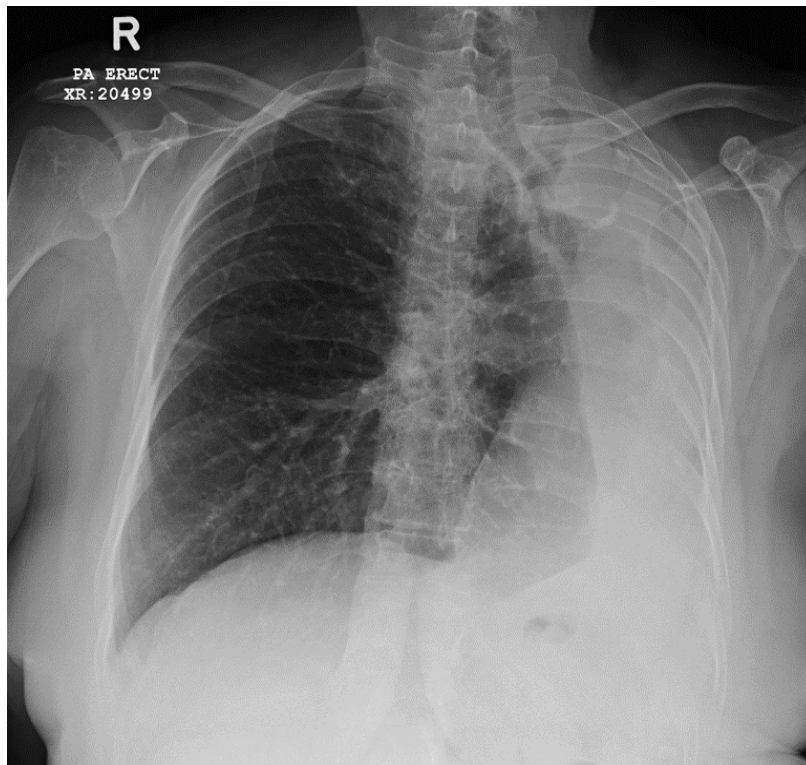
Plain Chest radiograph showing hyperinflation of the right lung with herniation towards the left thorax. There is gross tracheal and mediastinal shift to the left and crowding of ribs of the left thorax.
